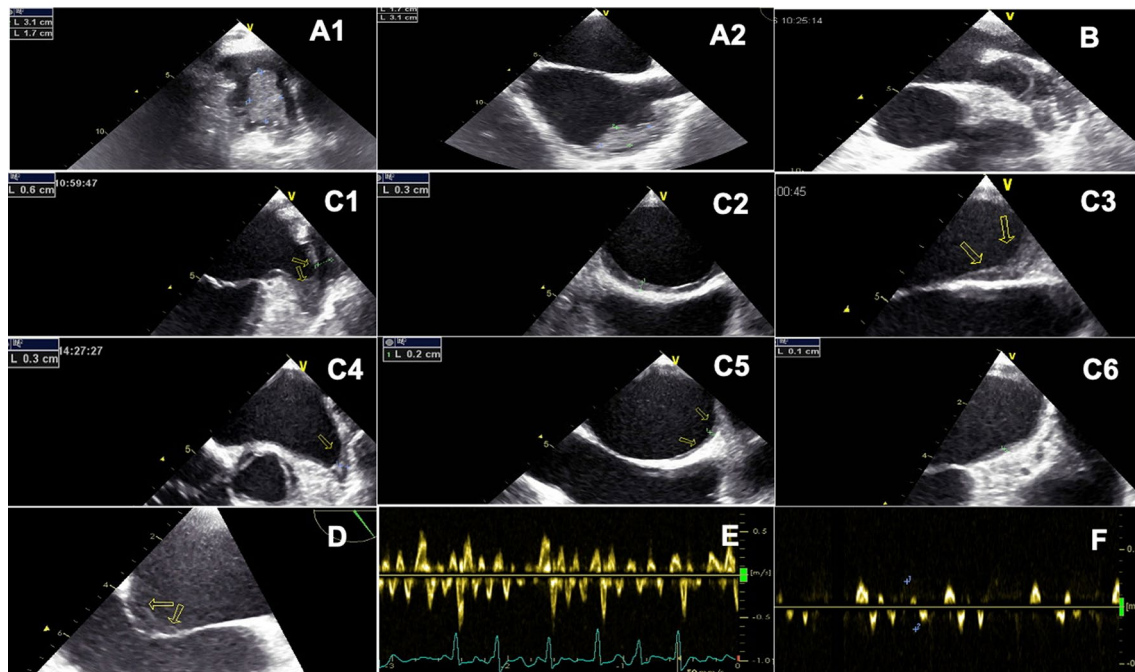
(A1, A2) Thrombus in the LAA and RAA extended into the bilateral atrial in the same patient. (B) Sludge is located inside LAA. (C1, C2, C3) Before anticoagulation, a solid lamellar thrombus was diffuse and attached to the LA, including the atrial septum and LAA. (C4, C5, C6) Thrombus decreased in the same patients who received anticoagulation for eight weeks. (D) Sludge in the atrial septal aneurysm is a protrusion of the interatrial septum into the RA. (E, F) Pulsed-Doppler tracing of LAA flow in an AF patient without thrombus/sludge; in an AF patient with thrombus/sludge
